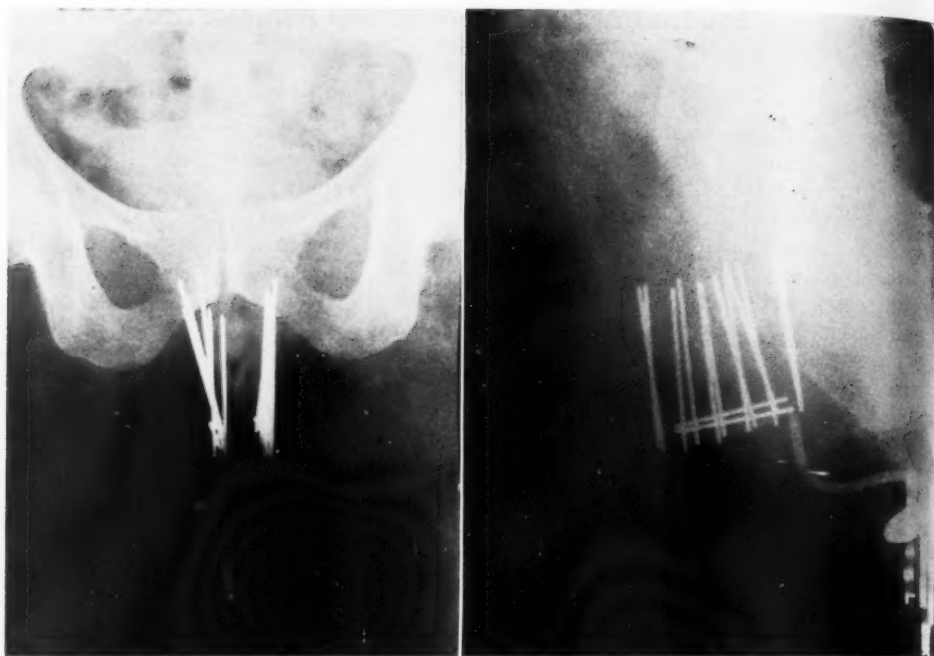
Anteroposterior and lateral radiographs (Case 13128). Separation of planes 2.3 cm. Average area of planes 20 sq. cm.
